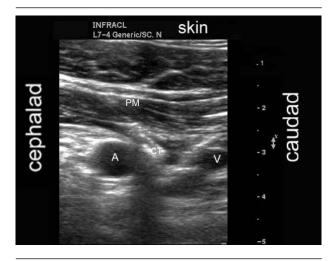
Catheter tip positioned between the artery and vein. PM = pectoralis muscle; A = axillary artery; V = axillary vein; CT = catheter tip.
